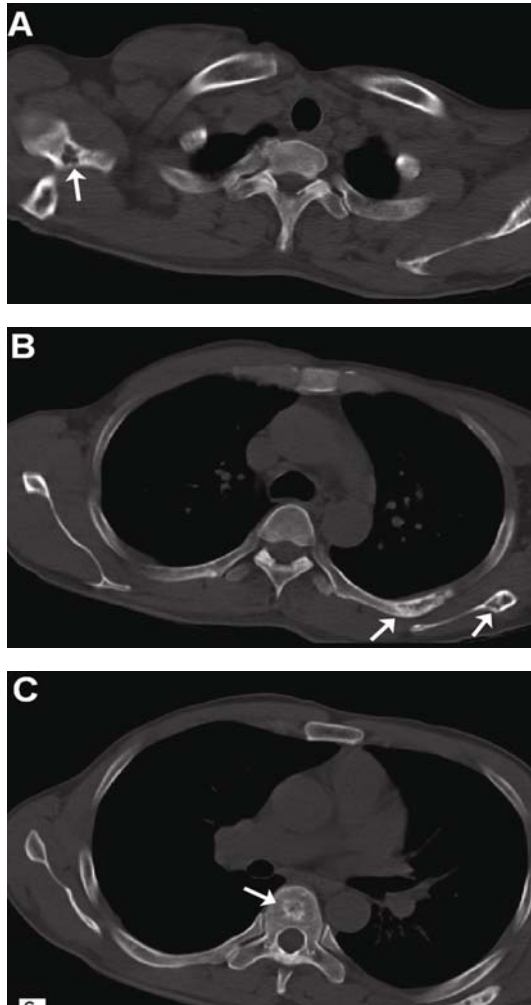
Chest CT of bone window showed eroded bone destruction with sclerotic edge in scapulas and ribs ((A): right scapula; (B): left scapula and the left 5th posterior rib) and patchy high density in thoracic vertebrae (C) However, the amount of the lesions was greater than that in Tc-99m MDP WBBS within the corresponding thoracic area. The bone lesions on CT with intensive Tc-99m MDP accumulation prompted multiple bone metastases.
